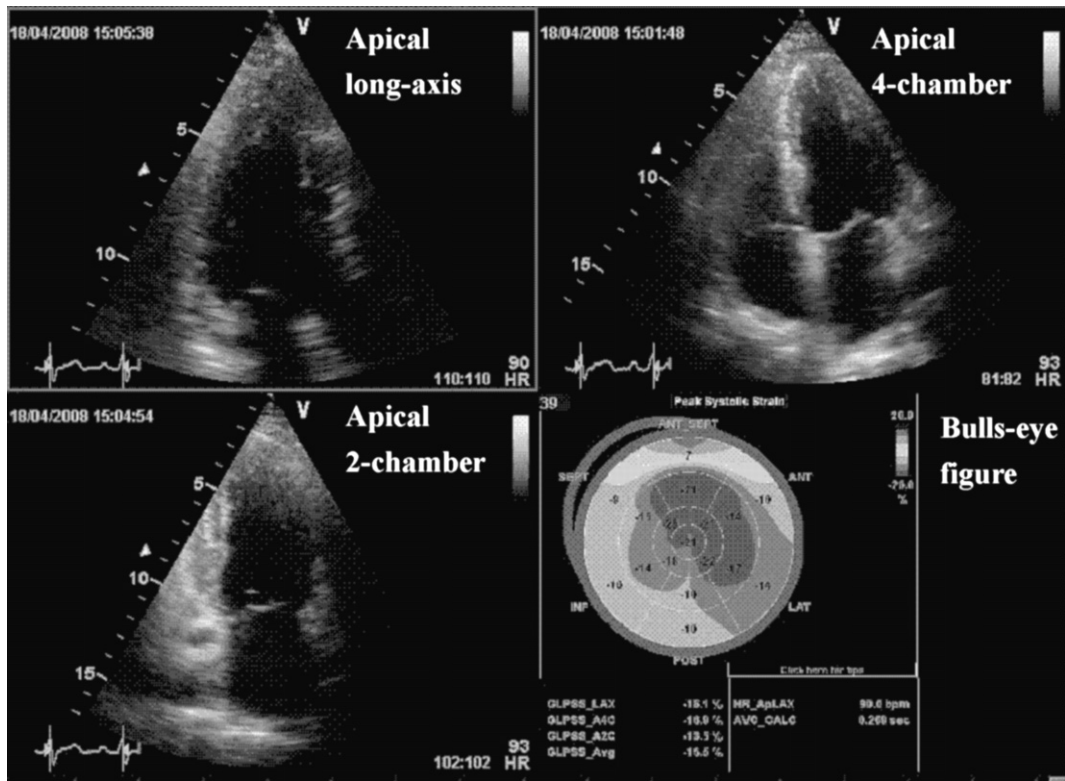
Example of global left ventricular peak systolic longitudinal strain graph. Values of the peak systolic longitudinal strain (PSLS) from the apical long-axis, apical 4-chamber (A4C), and apical 2-chamber (A2C) views were obtained automatically by AFI software. The average of the 3 values was regarded as global left ventricular peak systolic longitudinal strain (GPSLS_Avg).
